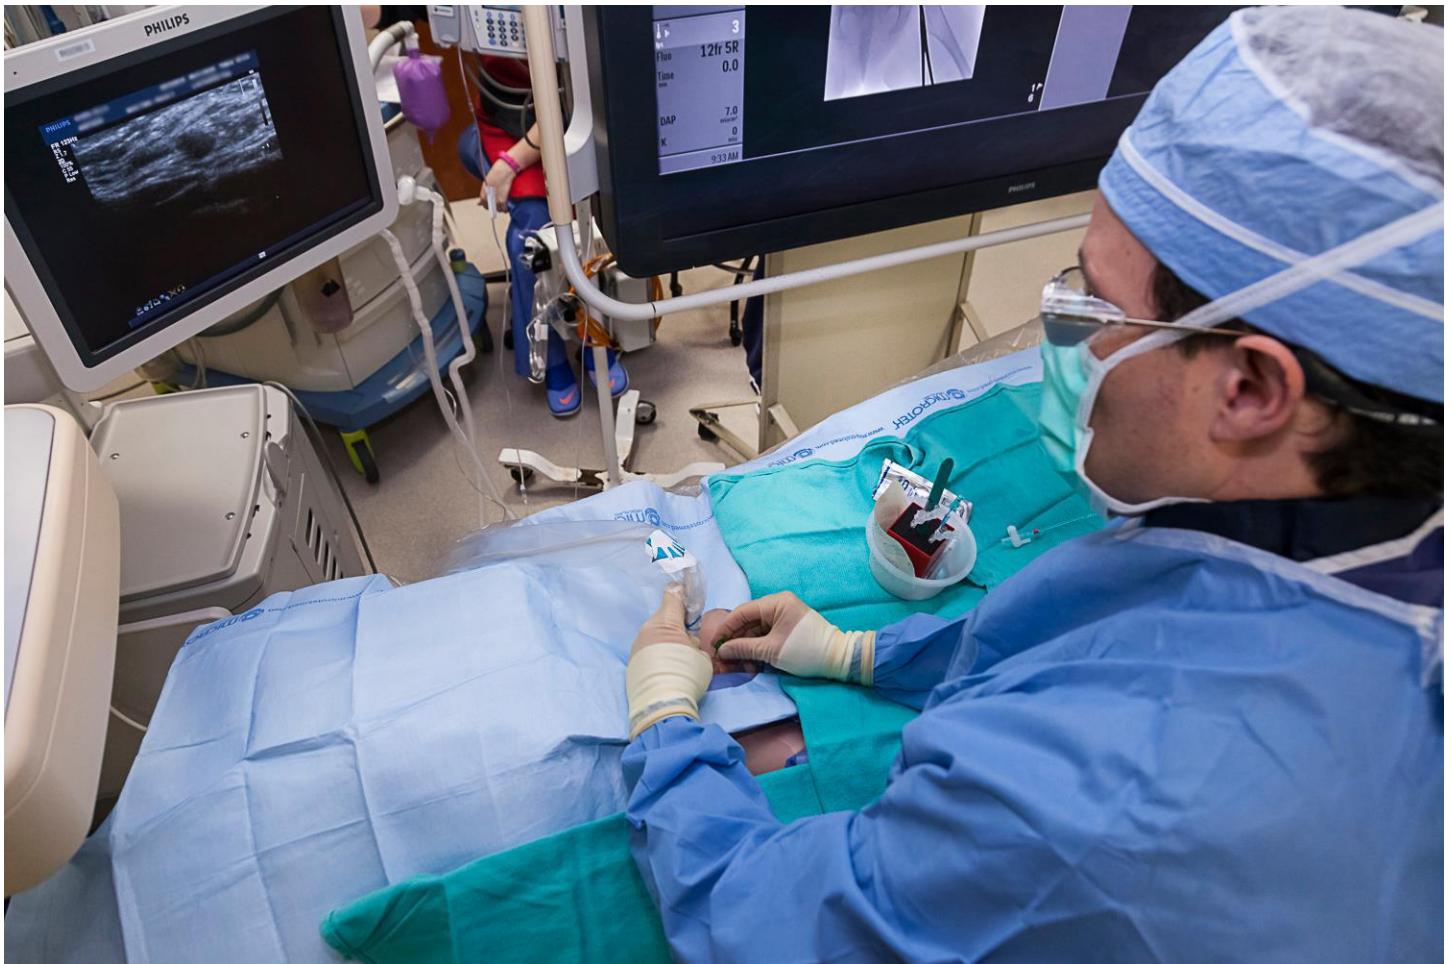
Image of a neuro-interventionalist accessing the femoral artery using ultrasound guidance and standard micropuncture kit.
